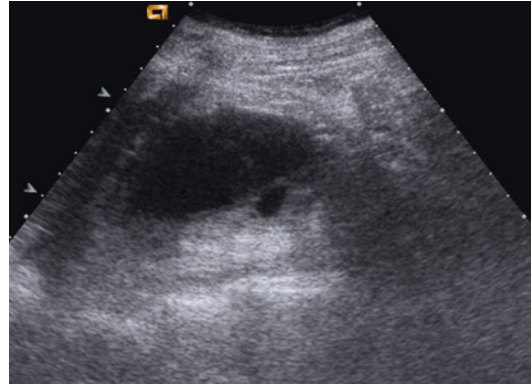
Ultrasound shows a non-recent subcapsular hematoma, which appears as an hypoechoic mass compressing renal parenchyma
